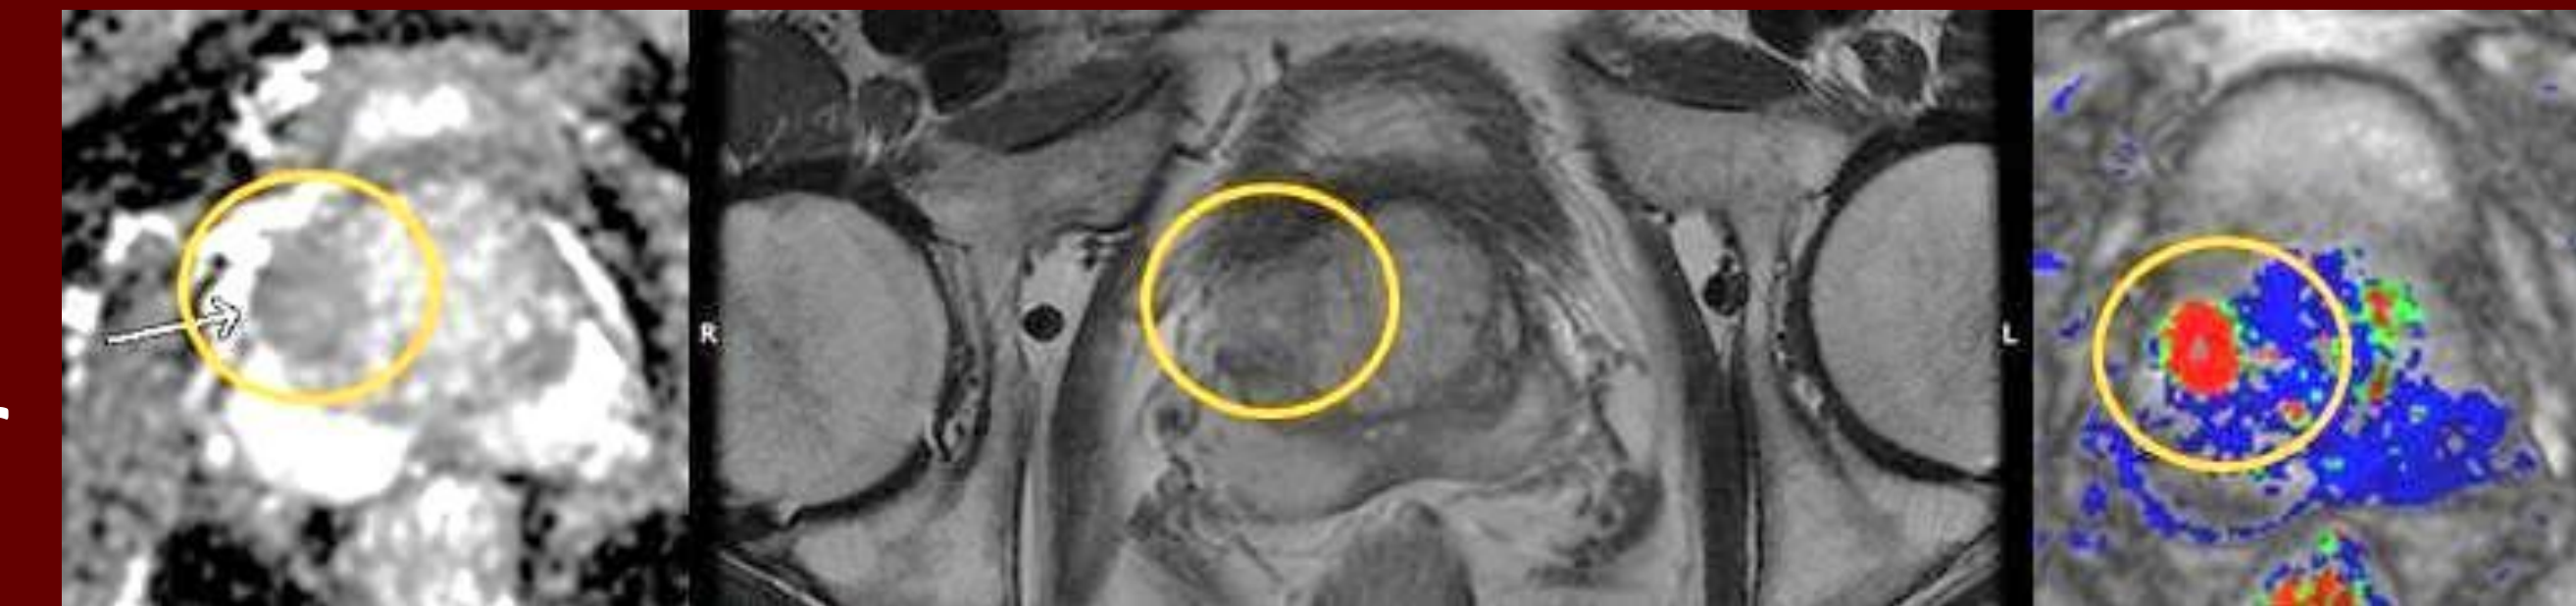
a & 3b : Suspicious focal lesion in prior-biopsy MRI
